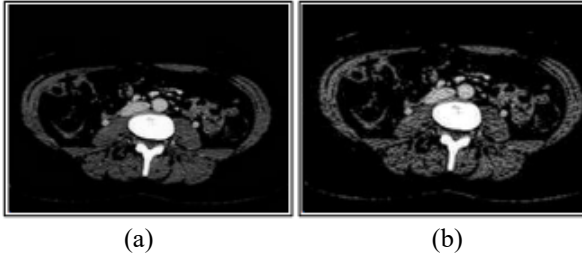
Results of the LPF (a) original CT slice (b) noise reduction.
